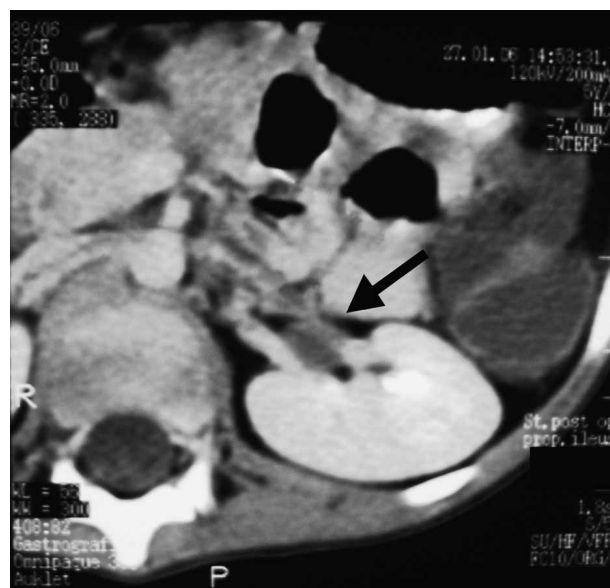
Abdominal CT scan showing the dilated upper part of left ureter (arrow). Extraureteral obstruction is excluded.
